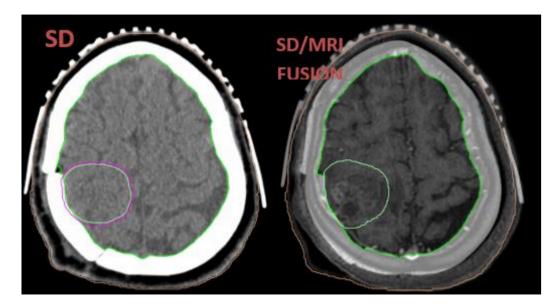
Delineation of the cavity of the resection of the brain metastasis on dosimetric CT scan (A) using fusion with initial brain MRI (B)
